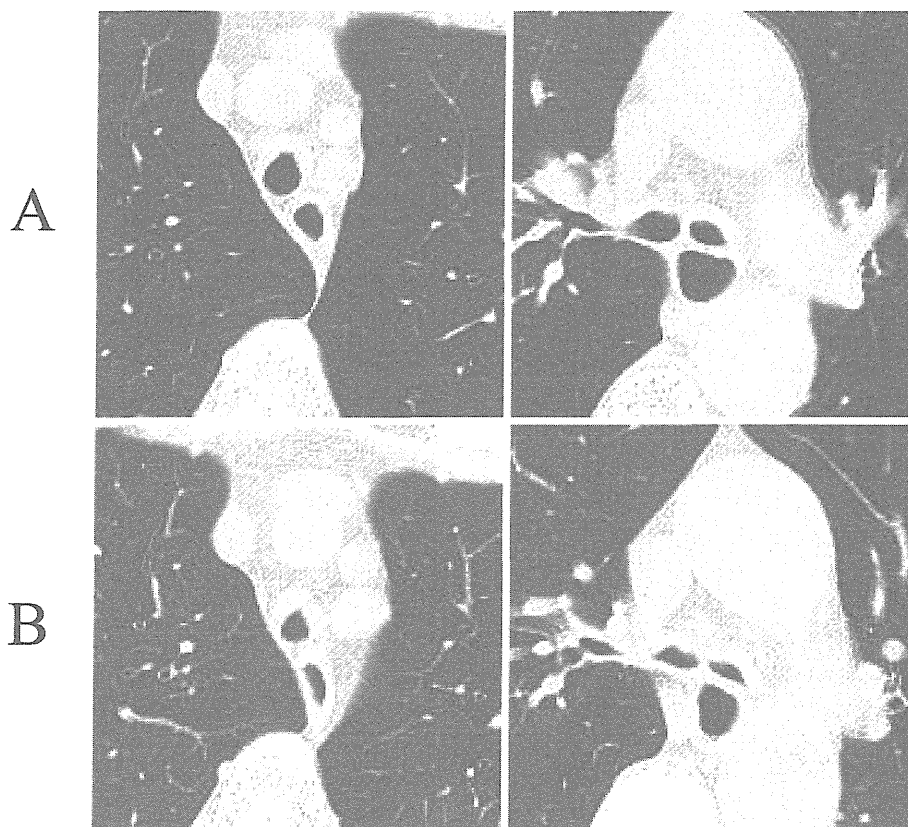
Transverse (A) end-inspiratory and (B) expiratory CT scans. Chest CT scans showing thickening and edema of the tracheal and bronchial wall. Both main bronchi show severe stenosis in an expiratory CT scan.
